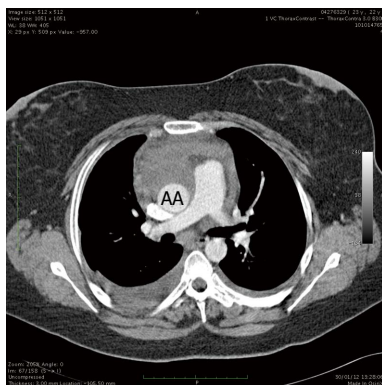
Axial plane computed tomography image of the ascending aorta. Axial image of the ascending aorta at the level of the pulmonary artery bifurcation. The ascending aorta is compressed in an oval shape due to the sub-adventitial spreading hematoma. AA: Ascending aorta.
